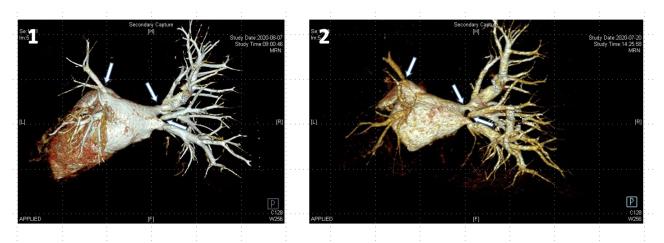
Pulmonary vien computed tomography angiography: the right middle pulmonary vein and both left superior and inferior pulmonary veins near the left atrium stenosis, especially the left superior pulmonary vein was almost occluded.(the diameter of venous entrance: left superior pulmonary vein 2.5mm, the inferior one 2.2mm; right superior vein 5.1, the middle one 2.5, the inferior one 6.6). The points that arrows refer to is the lesions.
